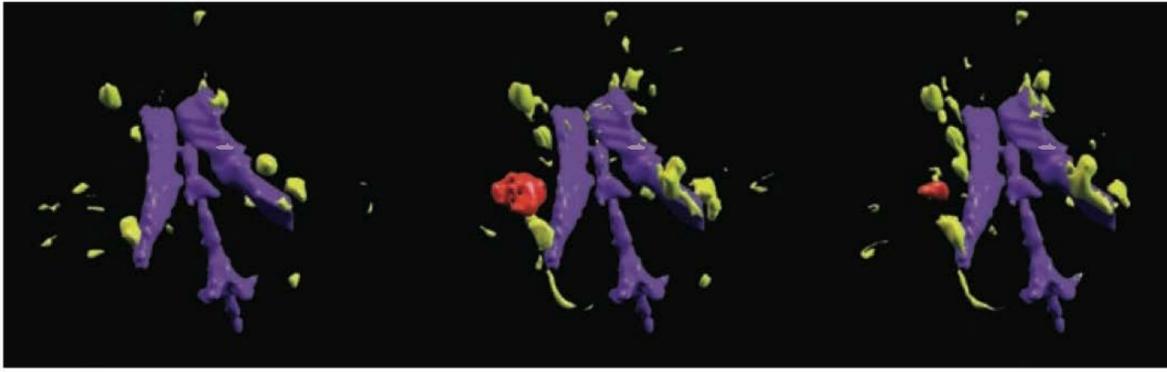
Three computer-generated images of MRI scans of the brain shown in Fig. 40.2 at the same time points. Several levels of MRI scans have been integrated by computer. The lateral and middle ventricles appear in purple. Old MS lesions appear yellow-green. A new, gadolinium-enhanced, lesion appears orange. On the right, this lesion has diminished in size after immunosuppressive therapy.
